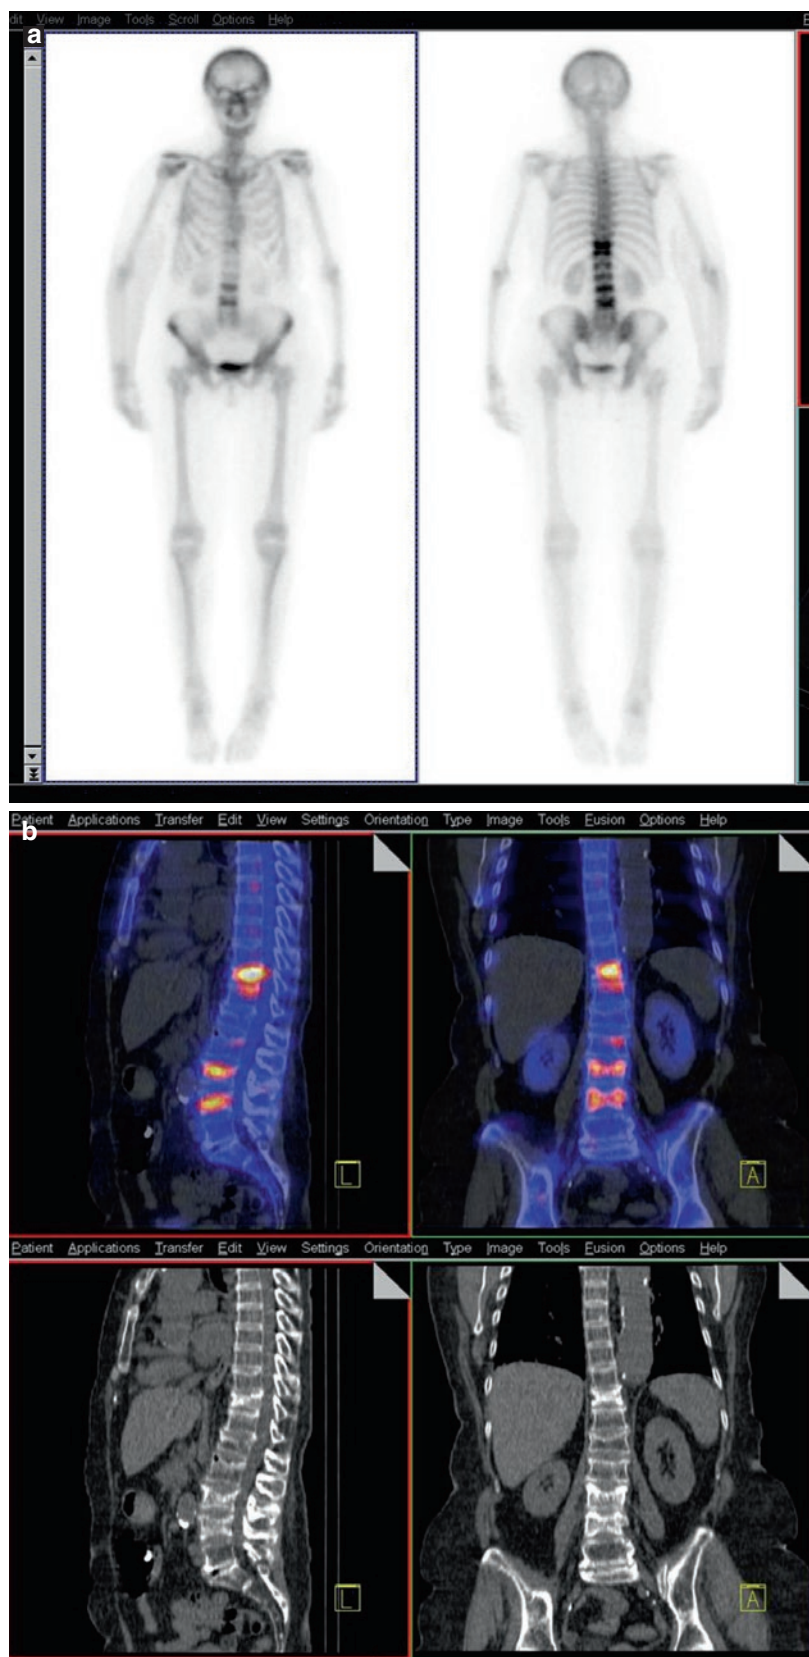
(a) Planar whole-body scintigrams in a patient with lumbar pain 3 years after diagnosis and treatment of breast cancer. (b) SPECT/CT fusion images (*upper row*) and matching CT images (*lower row*) of that patient. All foci of increased tracer accumulation correspond to compression fractures of the vertebrae, malignancy can be reliably ruled out in one hybrid imaging session
